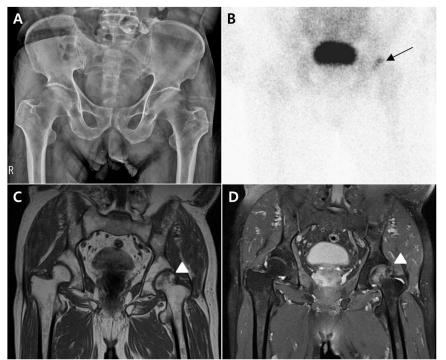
(A) Hip radiography revelaed no definite abnormality. (B) Whole body bone scan showed hot spot at the left femur head (arrow). (C, D) On MRI of the left hip, a diffuse bone marrow edema pattern (arrow head) is seen, with low signal intensity on T1-weighted imaging (C) and high signal intensity on T2-weighted imaging (D)
